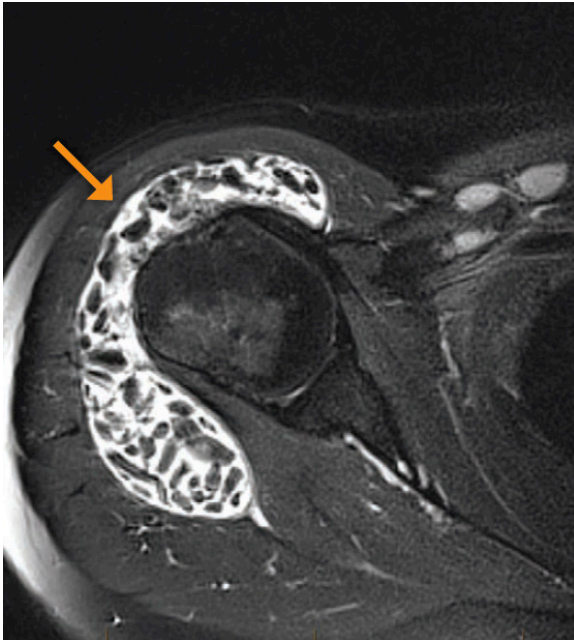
Patient with rheumatoid arthritis with complex bursitis evident on US. Characteristic Rice Bodies are present in the bursa. These are small loose bodies which occur as a result of chronic inflammation. MRI showed that there was no associated intra-articular pathology in this patient.
